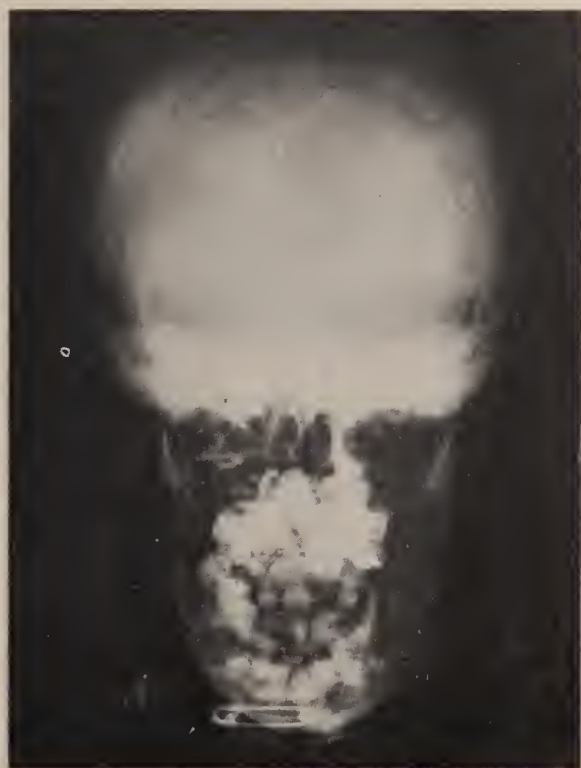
Antero-posterior roentgenogram of skull.
